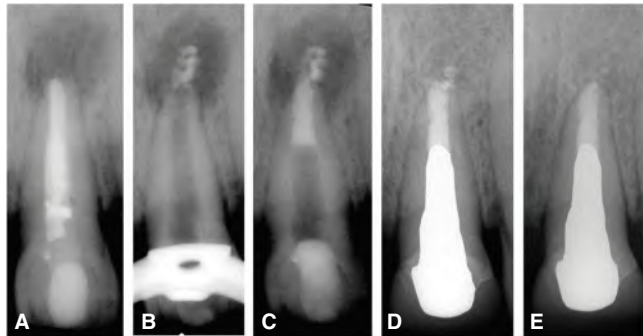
Endodontic retreatment in a maxillary central incisor of a 28-year-old male. The patient reported to have suffered traumatic injury to the tooth in childhood. A. Preoperative radiograph showing periapical radiolucency associated with the affected tooth. The patient was asymptomatic. B. Radiograph taken after removal of the previous root canal filling. Remnants of old filling material can be detected in the periapical area. C. Immediate postoperative radiograph. The apical part of the root canal was filled with MTA. D. Six-year follow-up radiograph showing marked reduction in size of the periapical radiolucency and in the amount of the extruded material. E. 10-year follow-up radiograph. Periapical radiolucency has resolved and extruded material almost completely reabsorbed.
